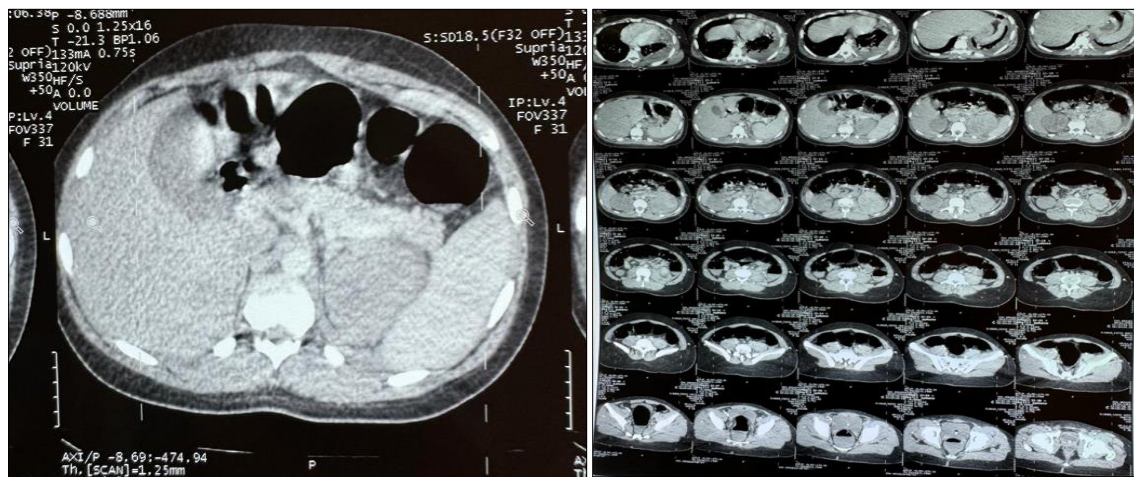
CT scan image of our case
